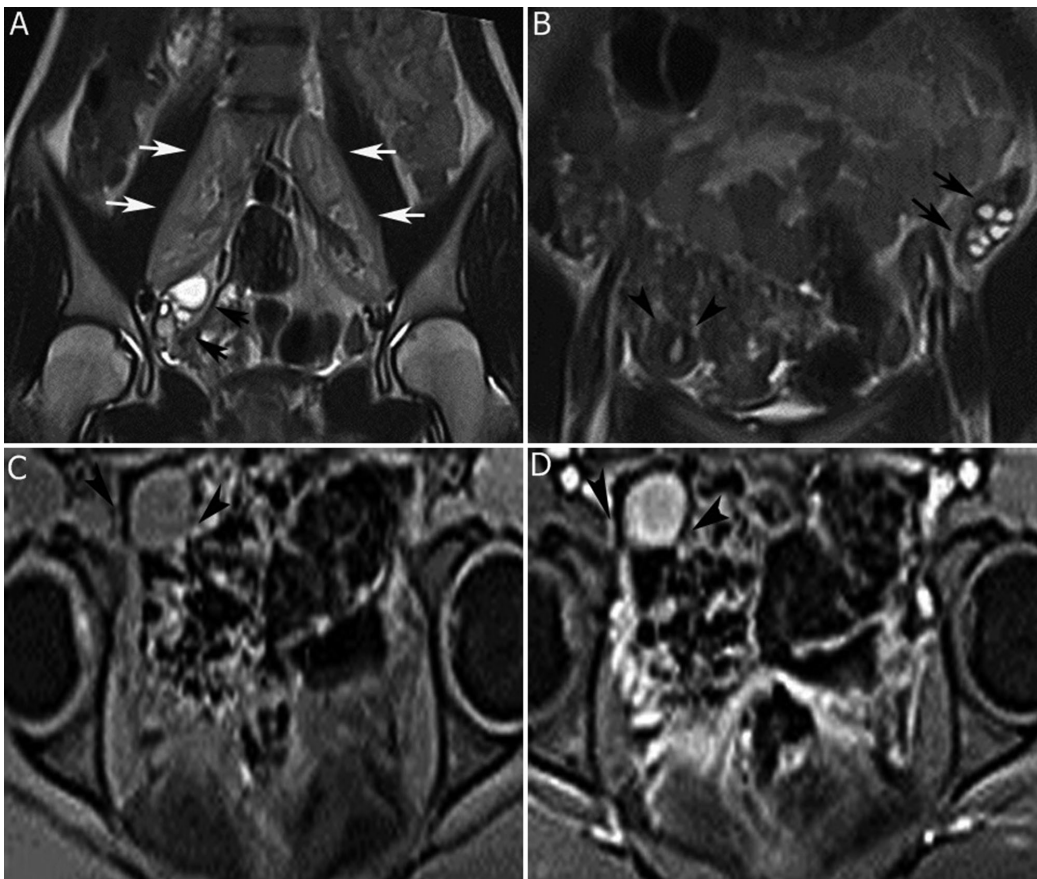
Figure a-d: T2-weighted coronal images (A, B) show bilateral ectopic-ptotic kidney with normal morphology (A, white arrows) and bilateral ovaries (A, B, black arrows). Both ovaries are morphologically normal but localized more superiorly. In addition, ectopic rudimentary uterus with thin linear endometrium is observed near the opening of the inguinal canal (B, black arrowheads). Pre-contrast and post-contrast fat-suppressed T1-weighted images (C, D) demonstrate enhancement of the rudimentary uterus (black arrowheads).
